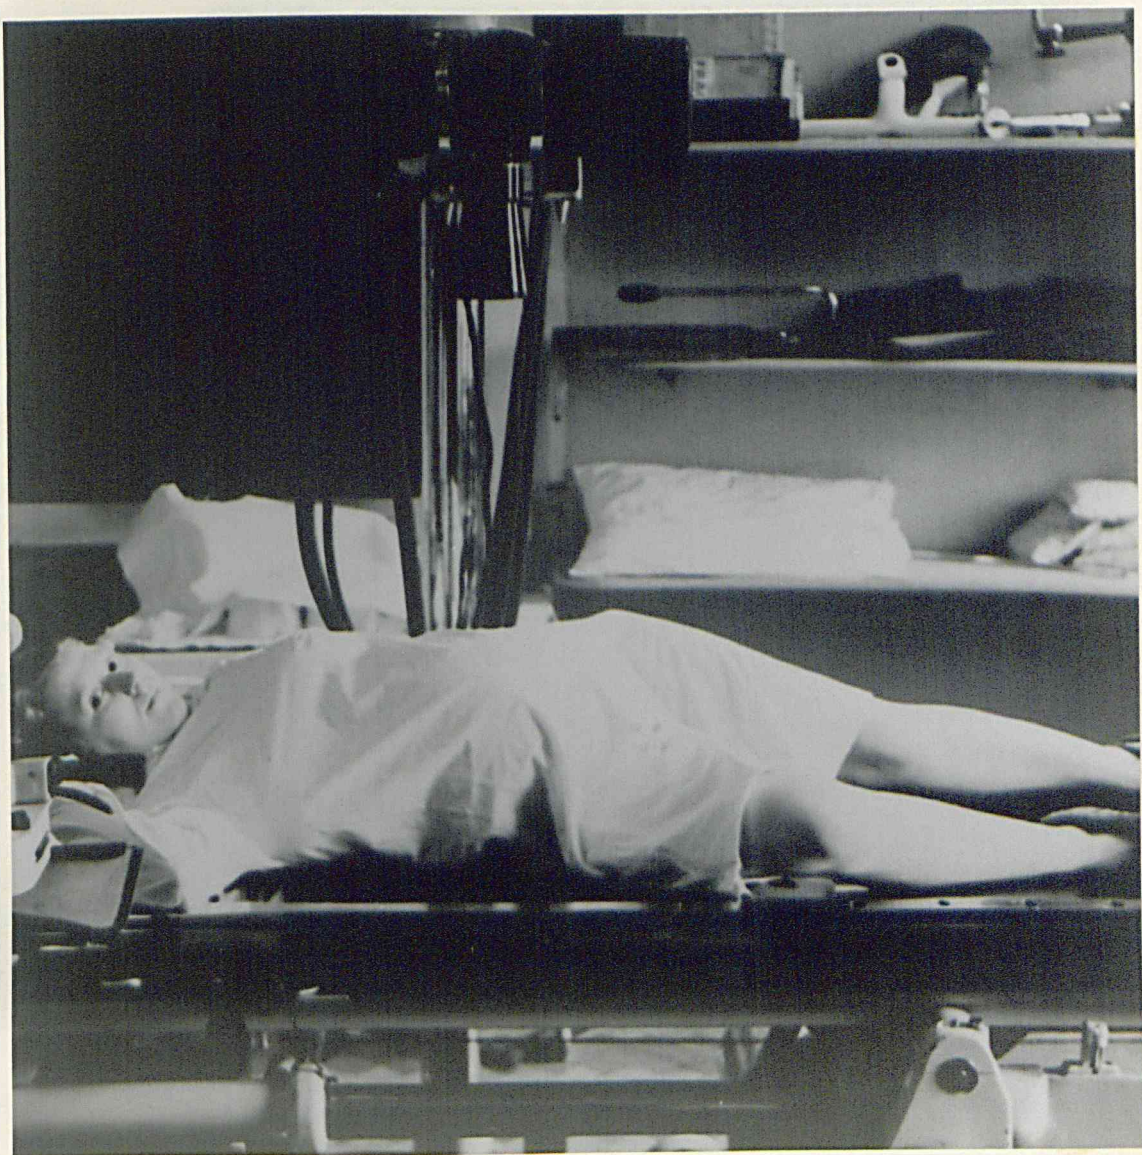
Patient positioned for the right oblique radiograph of the patient's abdomen.
